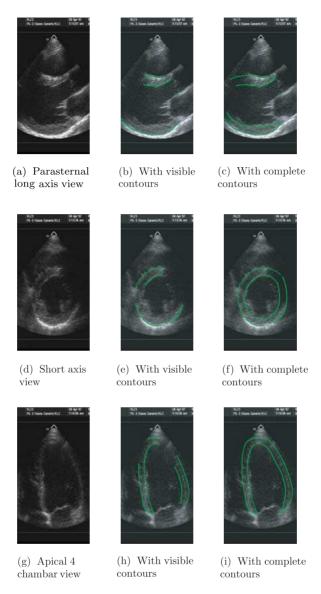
Ultrasound images of the left ventricle and surface model contours.
